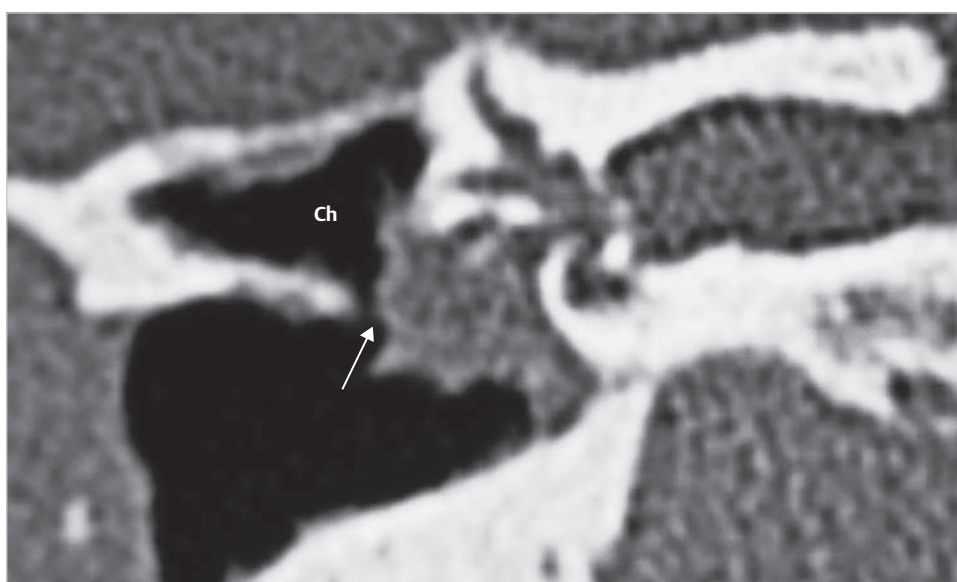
A case of recurrent cholesteatoma after canal wall up tympanoplasty performed elsewhere. The preoperative CT demonstrates destruction of bony wall (*arrow*) and accumulation of debris over the posterosuperior quadrant of the tympanic membrane. No aeration is seen in the tympanic cavity. Ch, cholesteatoma.
